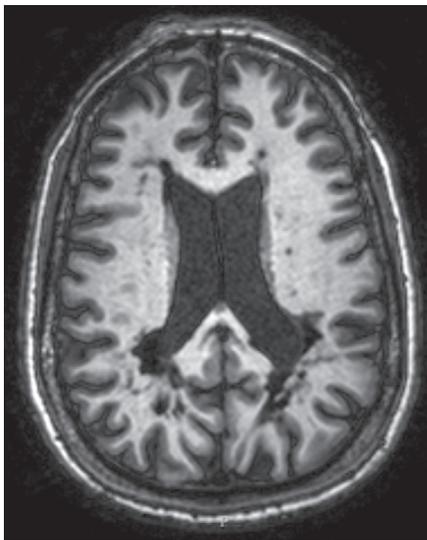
Axial T1-weighted image showing numerous areas of T1 low signal (“black holes”), ventricular enlargement, and diffuse atrophy.
